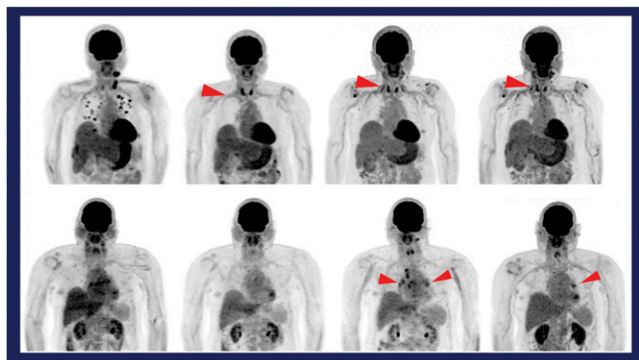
Potential role of ^{18}F -FDG PET/CT for early response assessment of immune-checkpoint inhibitors. Top: Patient with immune-related thyroiditis (arrowheads) imaged at (left to right) baseline and 3, 10, and 14 months after treatment initiation. Bottom: Patient with immune-related lymphadenopathy (arrowheads) at baseline and 2, 6, and 9 months after treatment initiation. The average peak of SUV_{max} was seen earlier in thyroiditis than in lymphadenopathy. Elevated ^{18}F -FDG uptake in thyroid may be a candidate sign for monitoring immunotherapy effectiveness.
